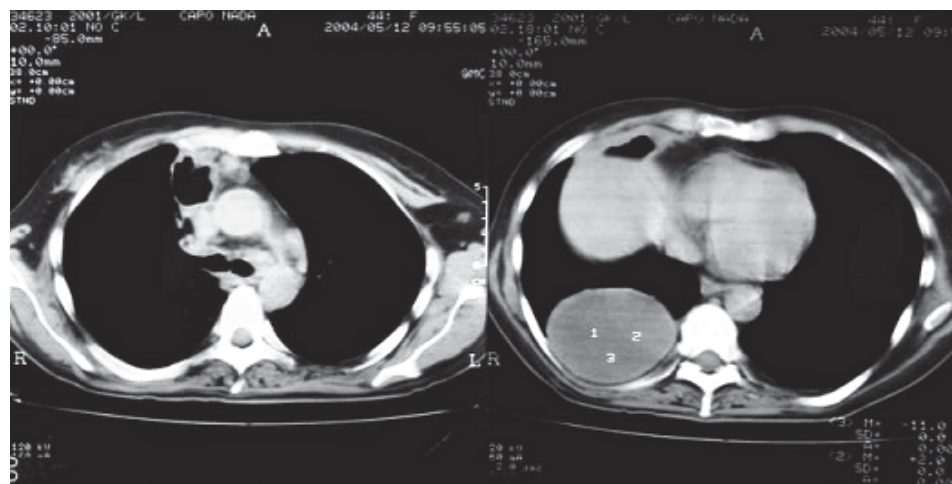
Computed tomography of the chest in the presented patient with disseminated *R. equi* infection after a month of combined antibiotic therapy.
